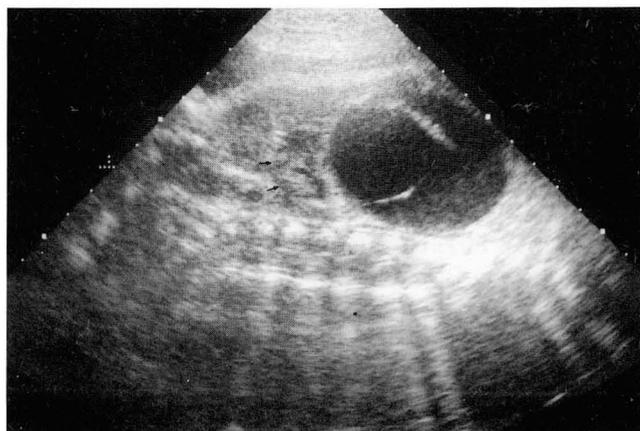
Longitudinal fetal sonogram at 37 weeks gestation shows well-defined anechoic mass with internal septa superior to the right kidney(arrows).
